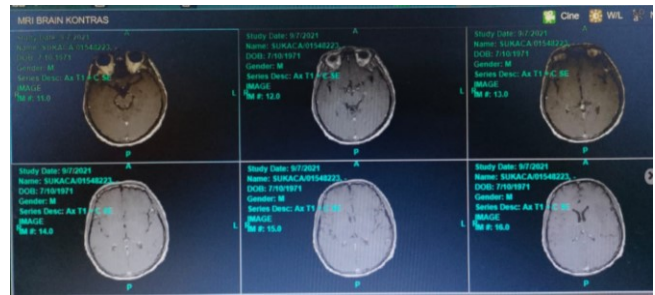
MRI of the Head with Axial section T1 + Contrast
